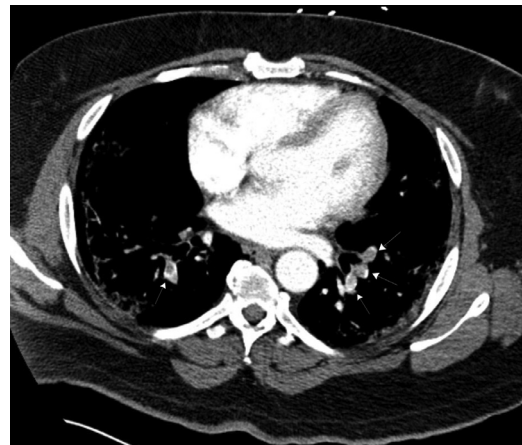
Computed tomography angiography (CTA) scan of the chest in axial view revealing multiple bilateral filling defects of the pulmonary artery in the lobar branches consistent with acute pulmonary embolisms (white arrows). Also revealing diffuse ground-glass opacities at the bases.
